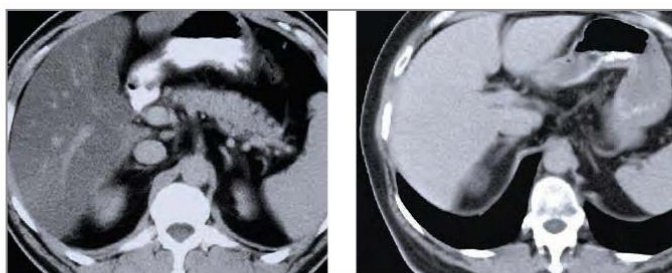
a CT: Fatty liver
